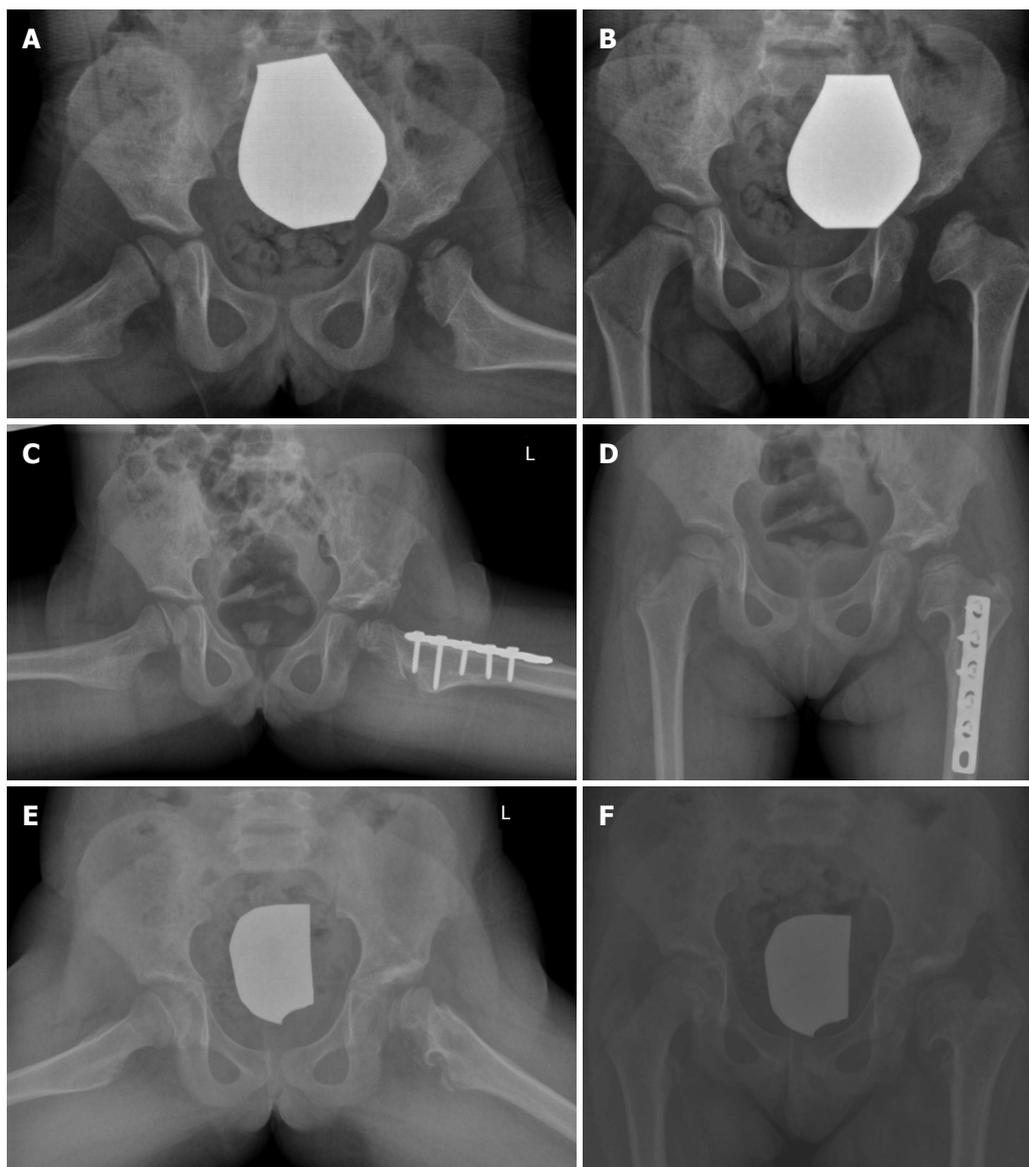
Acetabuloplasty. A female patient was diagnosed with DDH of the left hip at the age of 6 mo using sonography. She was treated with a spica cast. AVN of the left femoral head was seen on follow-up radiographs at the age of 3 years (A,B); C, D: Acetabuloplasty of the left hip with femoral derotational osteotomy was performed at the age of 5 years; E, F: Follow-up X-rays at the age of 8 years. DDH: Developmental dysplasia of the hip; AVN: Avascular necrosis.
